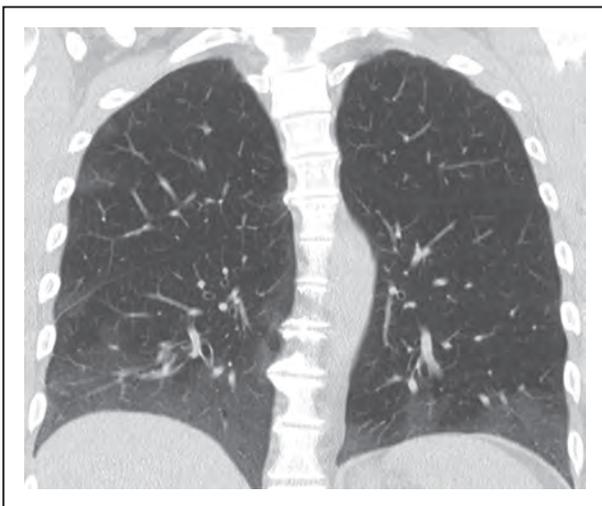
Desquamative interstitial pneumonia on CT. Coronal reconstruction showing relatively 'bland', nonspecific ground-glass opacification in both lower lobes. There were no convincing CT features of established fibrosis in this patient.
